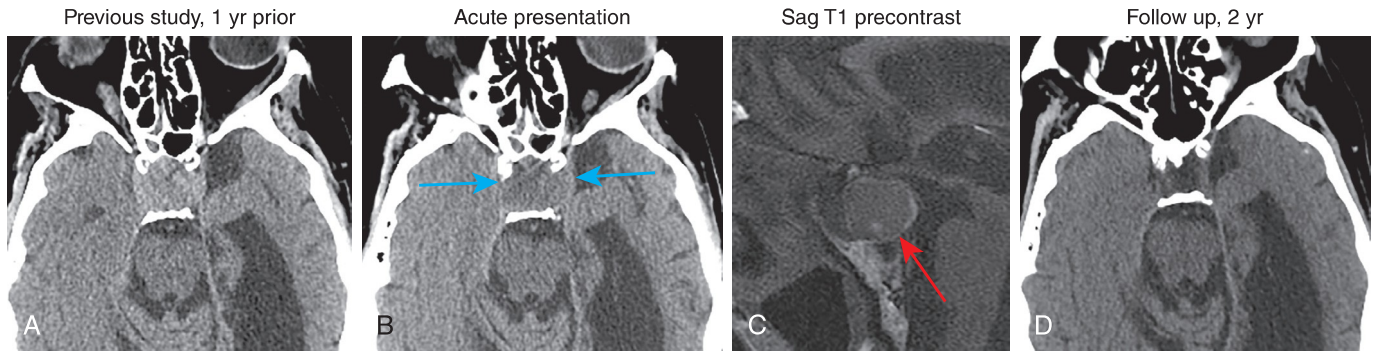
Ischemic pituitary apoplexy. A 71-year-old man with type 2 diabetes and a preexisting macroadenoma presented with acute lethargy, visual disturbance, and adrenal insufficiency. (A) Previous computed tomography (CT) performed 1 year prior demonstrates a mildly hyperdense pituitary macroadenoma expanding the sella. (B) Acute presentation CT demonstrates interval decrease in density of the macroadenoma compatible with nonhemorrhagic infarction (*blue arrows*). (C) Sagittal T1 precontrast magnetic resonance imaging demonstrates a small focus of T1 hyperintensity within the macroadenoma, consistent with a small amount of internal hemorrhage (*red arrow*). (The patient was unable to tolerate postcontrast imaging.) (D) Two-year follow-up study after transsphenoidal resection due to progressive visual disturbance during the acute episode demonstrates cerebrospinal fluid density within the expanded sella. The pathology was consistent with necrotic adenoma. The patient continues to receive hormone replacement therapy.
